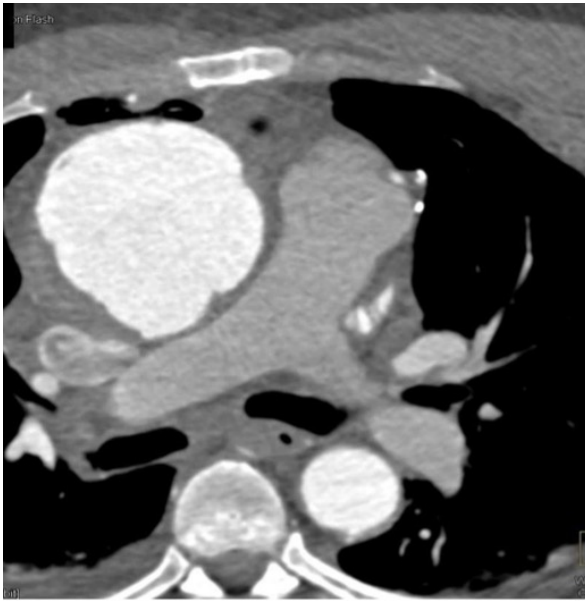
Preoperative Computed Tomography (CT) angiography. Axial CT scan showing a large pseudoaneurysm (10 × 4.8 cm) arising from the ascending aorta, compressing the main pulmonary artery, and eroding the sternum.
